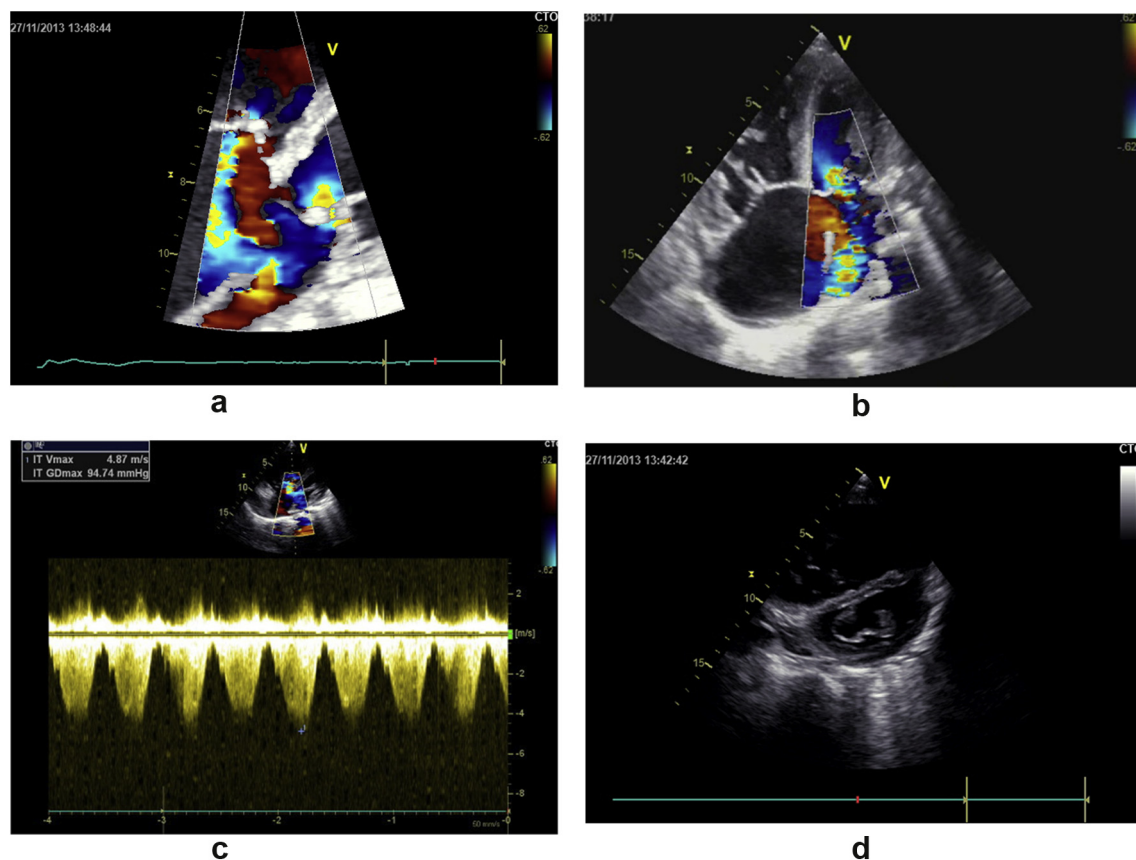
a: Echocardiography Doppler showing an ostium primum atrial septal defect with a right-to-left shunt. b: Echocardiography: apical view with colour Doppler showing grade III mitral regurgitation. c: Echocardiography: continuous Doppler estimating right ventricular systolic pressure to 100 mmHg. d: Echocardiography: parasternal short axis view showing paradoxical septal motion.
